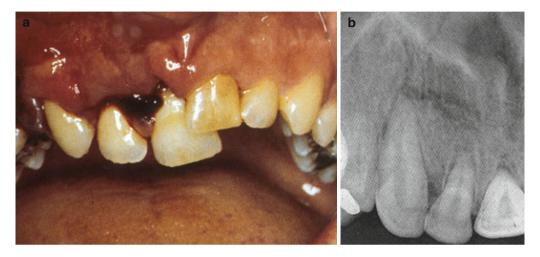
Radiographs are required to identify dentoalveolar fractures (a, b). Otherwise these can be confused with luxation of the teeth
